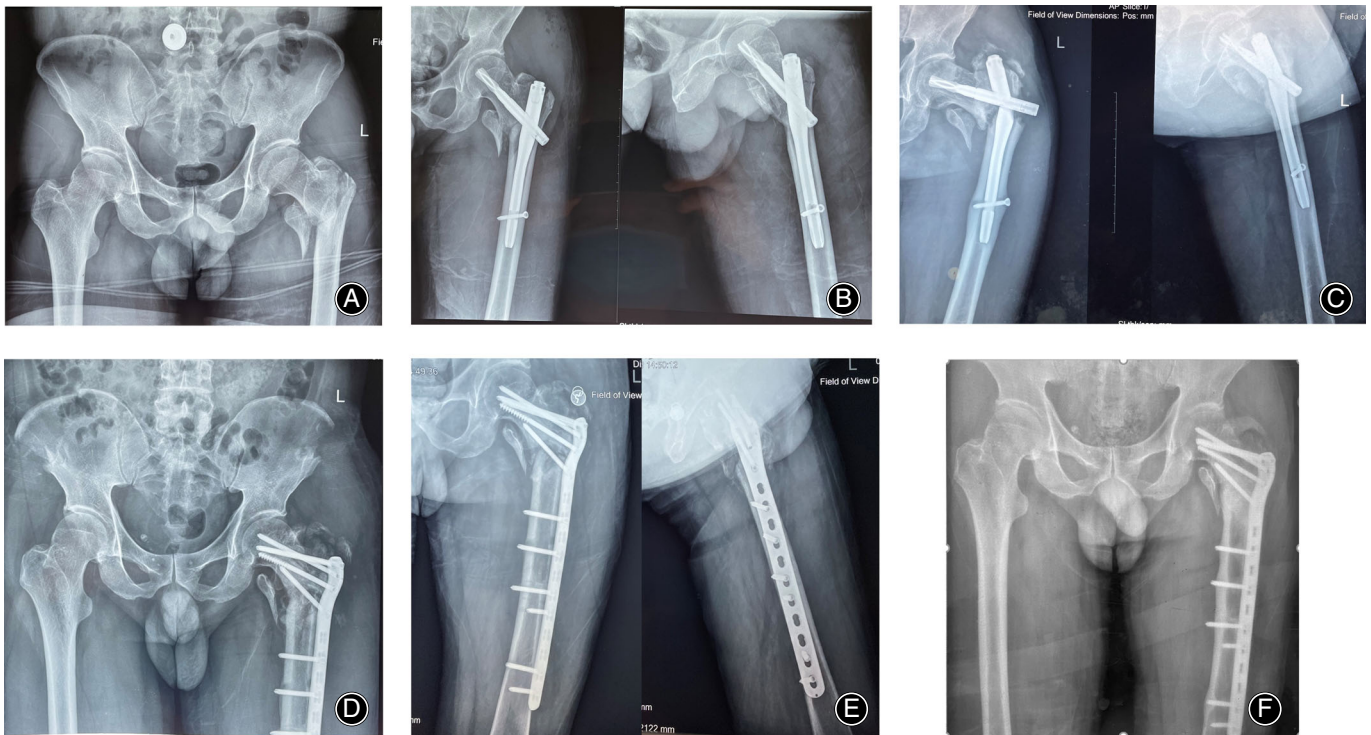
A 52-year-old male patient with initial left intertrochanteric fracture (type A2) 18 months after fixation with PFNA accepted the second surgery with PFLP revision for the failure of initial fixation. (A) Preoperative anteroposterior X-ray of pelvic. (B) Anteroposterior and lateral X-rays at immediate after the internal fixation of PFNA. (C) Anteroposterior and lateral X-rays at 18 months after fixation of PFNA, showed the failure of PFNA. (D) Anteroposterior X-ray of pelvic at 3 months after revision with PFLP. (E) Anteroposterior and lateral X-rays of the hip at 6 months after revision with PFLP. (F) Anteroposterior and lateral X-rays of the hip at 2 years months after revision, showed the fracture had healed.
